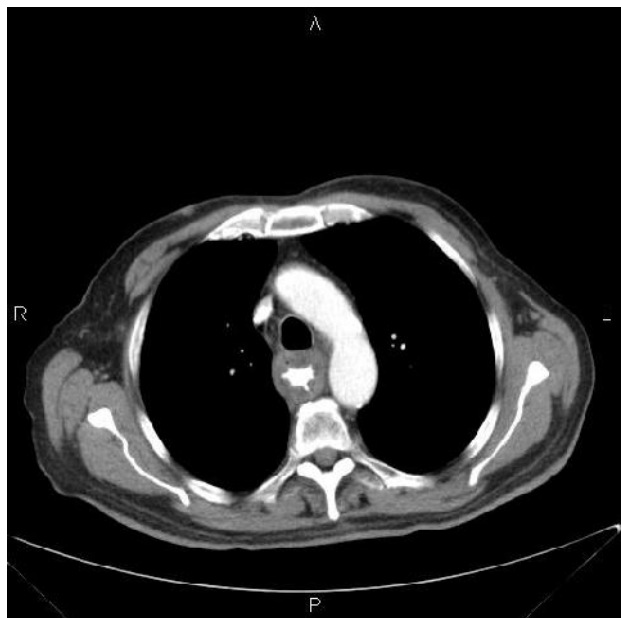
Post procedure CT
